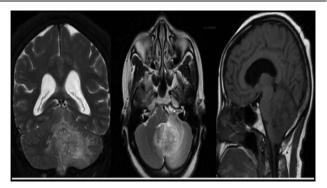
MRI Brain: Heterogeneous hyperintense mass (coronal T2- and axial T2-weighted images) and iso-hypointense mass (sagittal T1-weighted image), with peripheral edema and narrowed, displaced fourth ventricle (dilated ventricles visible in sagittal T1-weighted image).
